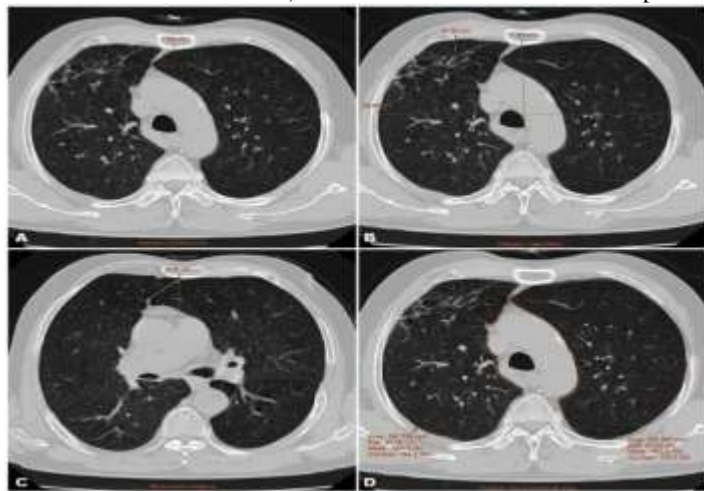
Detailed chest computed tomography showing quantitative COPD features. A: Anterior junction line. B: Thoracic cage ratio. C: Sterno-aortic distance. D: Thoracic cross-sectional area.
